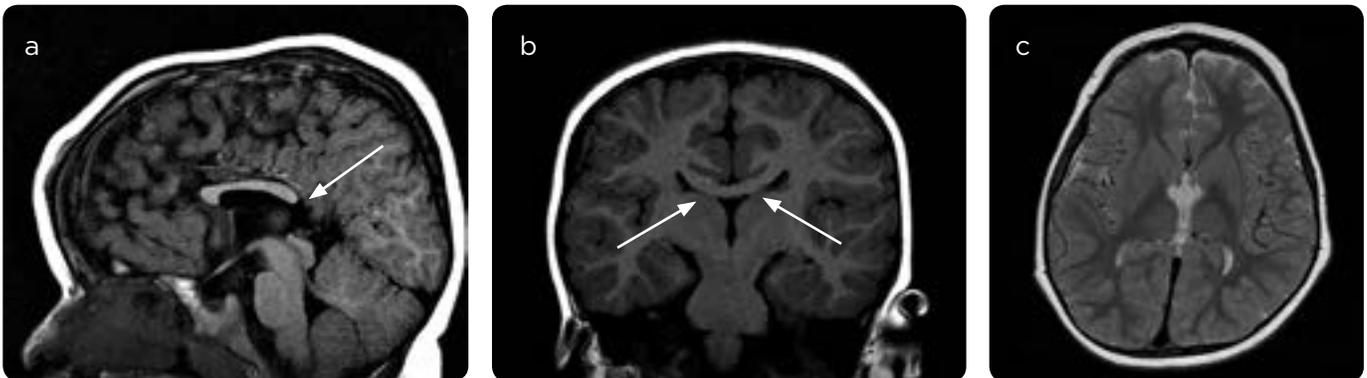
a) Sagittal MRI T1 sequence FLAIR: absence of splenium (arrow). b) Coronal MRI T2 sequence FLAIR: sign of "Viking helmet" (arrow). c) Axial MRI T2 sequence: colpocephaly (arrow).
